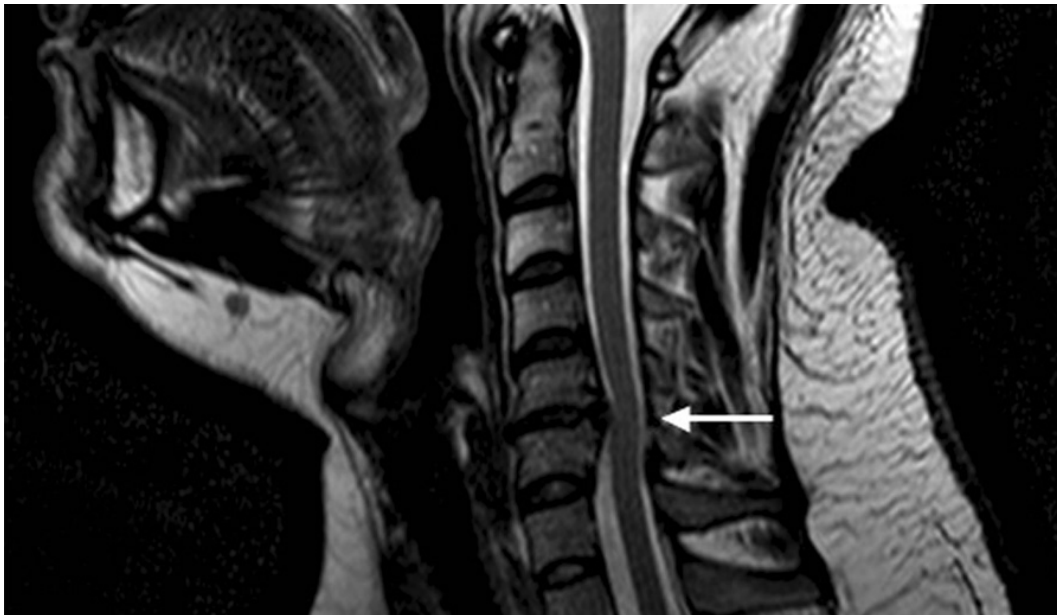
Pre-operative MRI scan. The arrow on the sagittal T1-weighted cervical spine image shows the central canal is severely narrowed (Yeung *et al.*, 2012)
